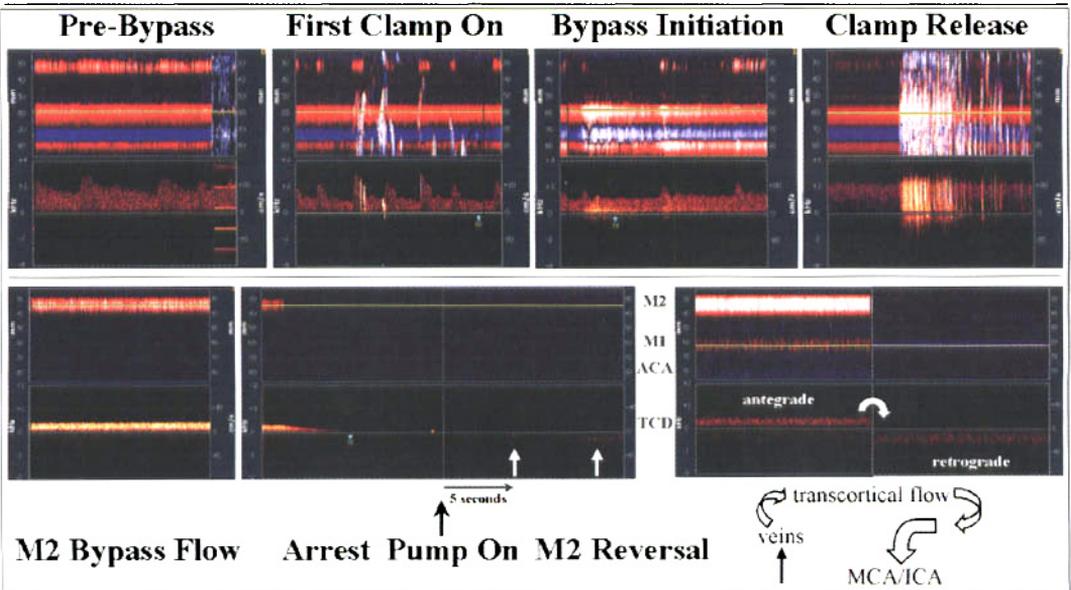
Prebypass (upper left image) flow has a low-resistance signature on the M-mode transcranial Doppler (TCD) that also shows antegrade M2, M1 MCA flows as well as the A1 ACAs’ flow. The artifact at the end of the sweep is caused by electrical cautery.
